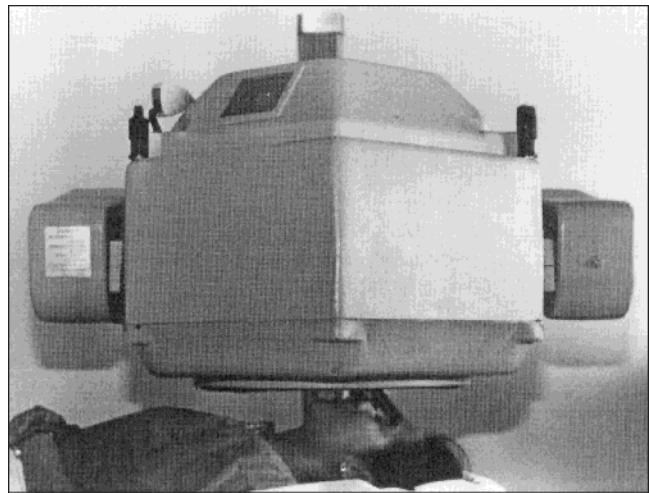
Patient's supine position for salivary gland scintigraphy with a slightly reclined head under a large field-of-view gamma camera.
